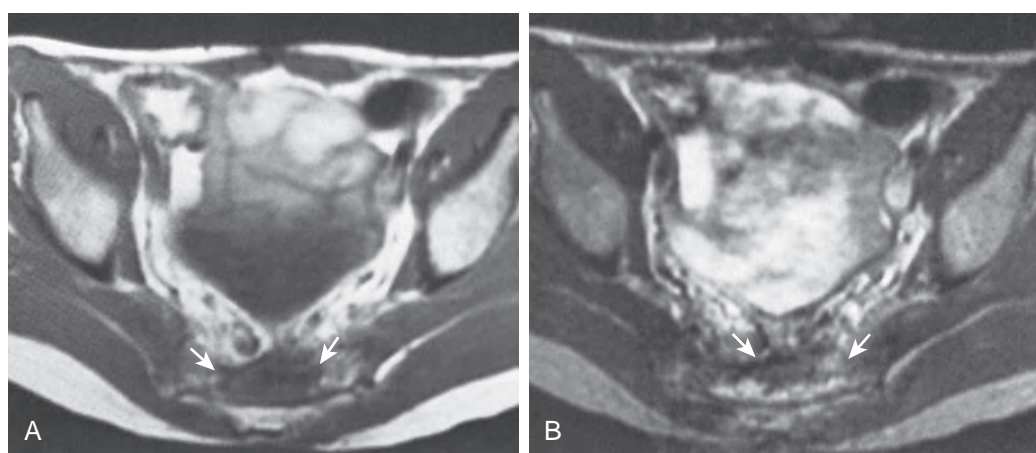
Indeterminate MRI scans of recurrent carcinoma after total colectomy. A. T1-weighted spin-echo image (700/20). An area of low signal intensity mixed with some intermediate signal intensity (*arrows*) is seen in the presacral space. B. T2-weighted spin-echo image (2500/70). The presacral soft tissue mass has intermediate signal intensity on T2-weighted scans (*arrows*). This is an indeterminate result and could represent recurrent viable tumor with a moderate amount of fibrous stroma, mild tumor necrosis, inflammation, or granulation tissue after surgery, irradiation, or both.
